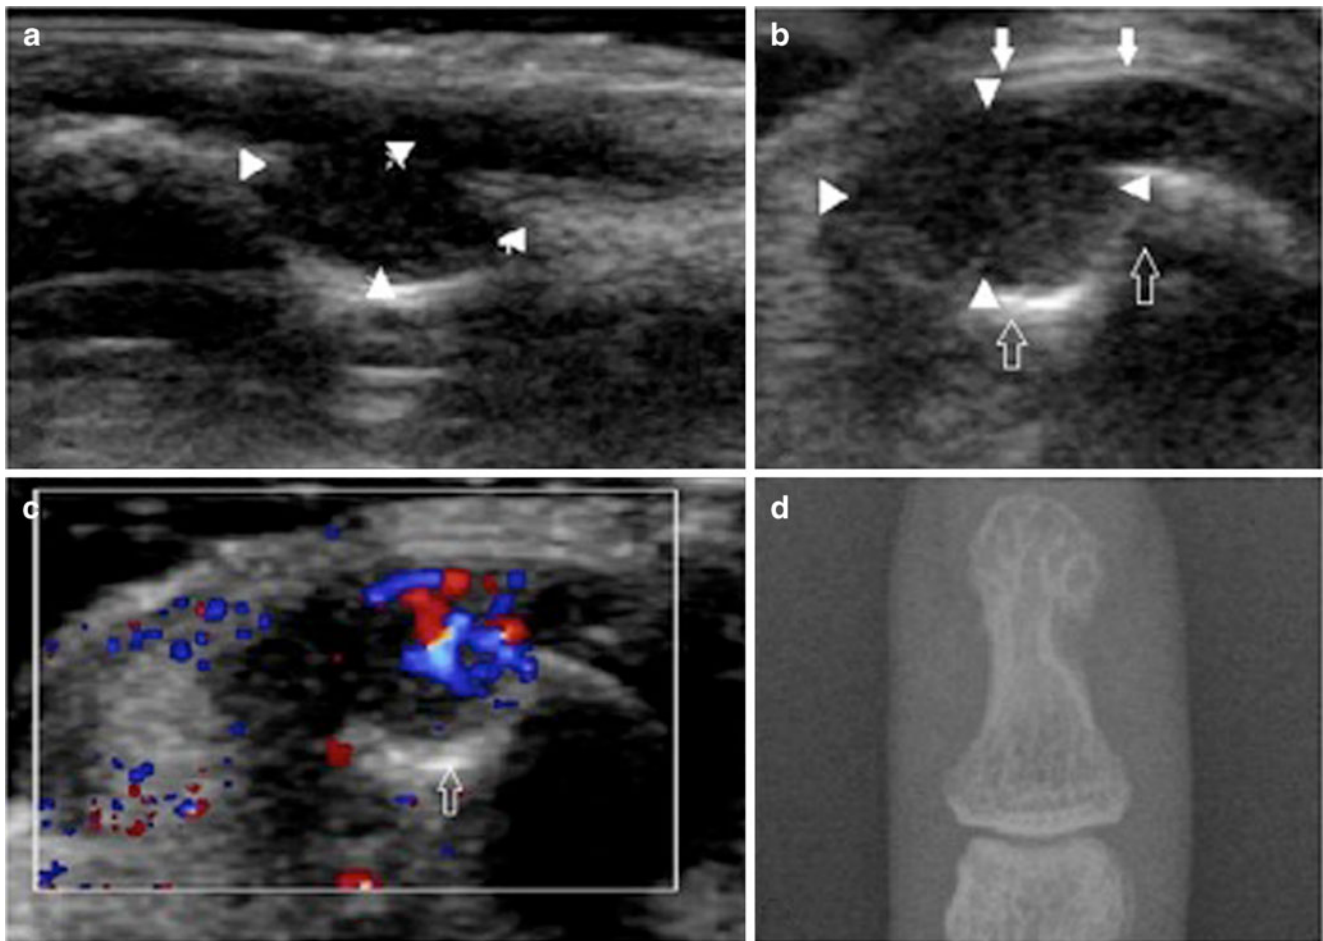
Glomus tumour. a Sagittal ultrasonographic images demonstrate a solid ill-defined lump, which has eroded into the distal phalanx. b Transverse ultrasonographic image demonstrates a lump with intermediate echogenicity eroding on one side of the bone but the nail structure not changed. It reveals the site and the extent of the erosion and the spread of the swelling into the surrounding structures. c The Doppler images
